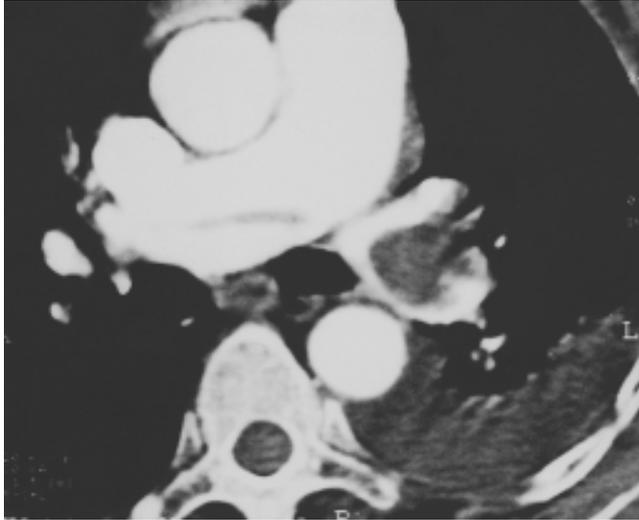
CTA showing intra luminal filling defect in right main pulmonary artery and left descending pulmonary artery with left pleural effusion
